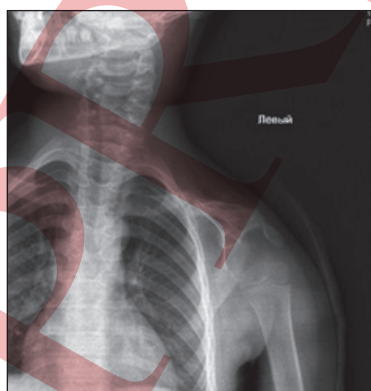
X-ray of a 9-year-old patient T. Hypoplasia of the left scapula's glenoid, hypoplasia of the distal part of the left clavicle, subluxation of the left humeral head downward and backward.
